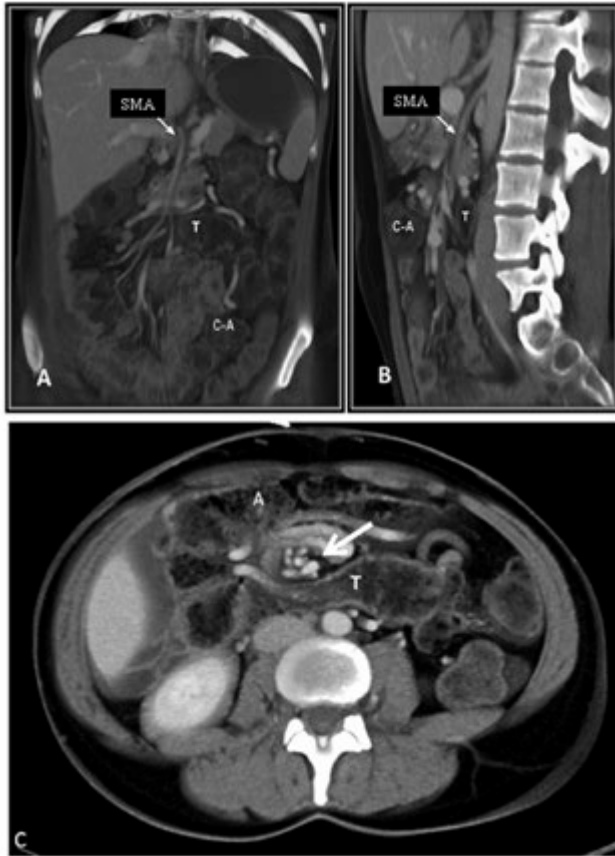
Abdominal contrast enhanced computer tomography (CT) with three-dimensional (3D) volume rendering (VR) reconstruction confirmed intestinal malrotation. A, B: 3D coronal (A) and sagittal (B) VR images show left side localization of right colon, and reverse rotation expressed by transverse colon (T) running posterior to the superior mesentery artery (SMA, arrow) and to the caecum and ascending colon (C-A). C: Axial 3D VR of contrast enhanced abdominal CT. Transverse colon (T) is recognizable posteriorly to SMA and to ascending colon (A). Superior mesenteric vein shows a whirling pattern (“barber pole sign”) (arrow).
